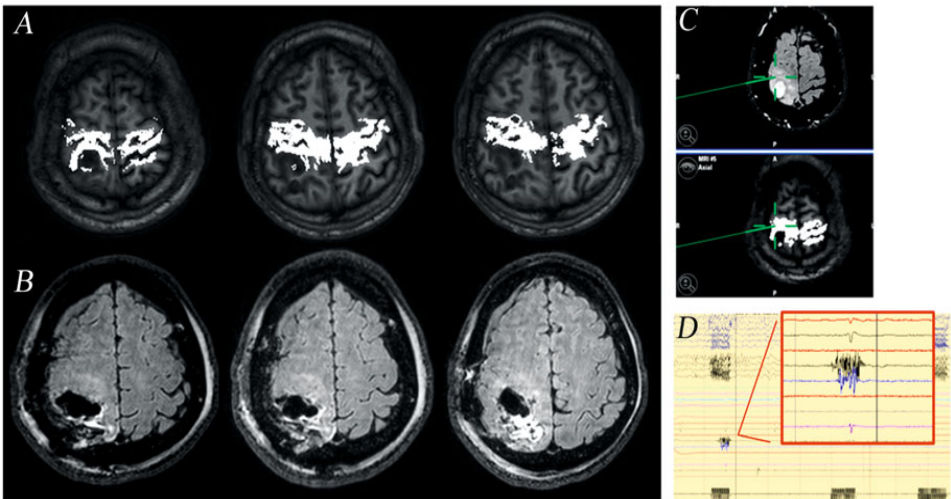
(A–D). CST reconstruction in a case of right parietal low-grade oligodendroglioma. (A) The CST (white bundle) was reconstructed by DTI-FT and superimposed on morphologic T1-weighted images; the CST was dislocated and infiltrated by the tumor mass. (C) The CST was identified intraoperatively by DES where the CST was located by DTI FT. (D) Example of motor response at subcortical level (hand). (B) Postoperative FLAIR images show that the margin of resection was coincident with the CST
